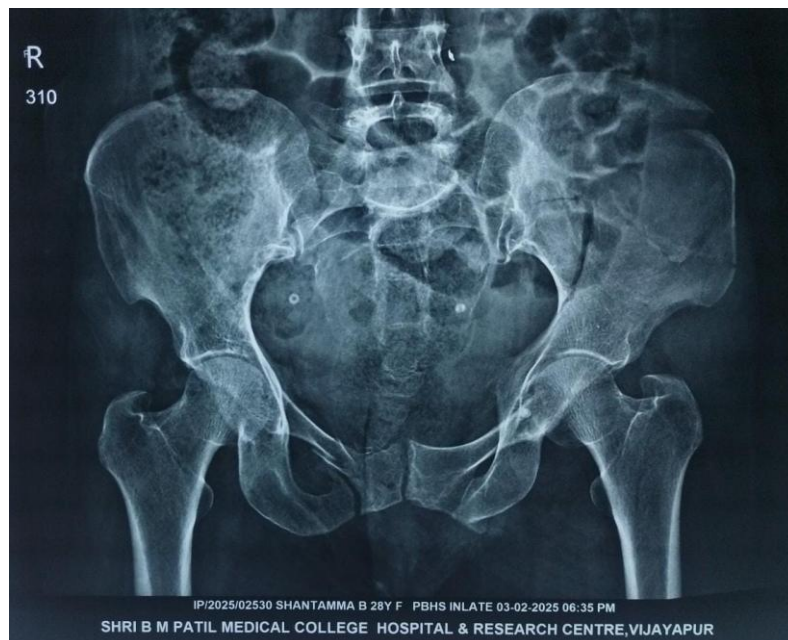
X-ray PBHS showing left Anterior column and iliac wing fracture
